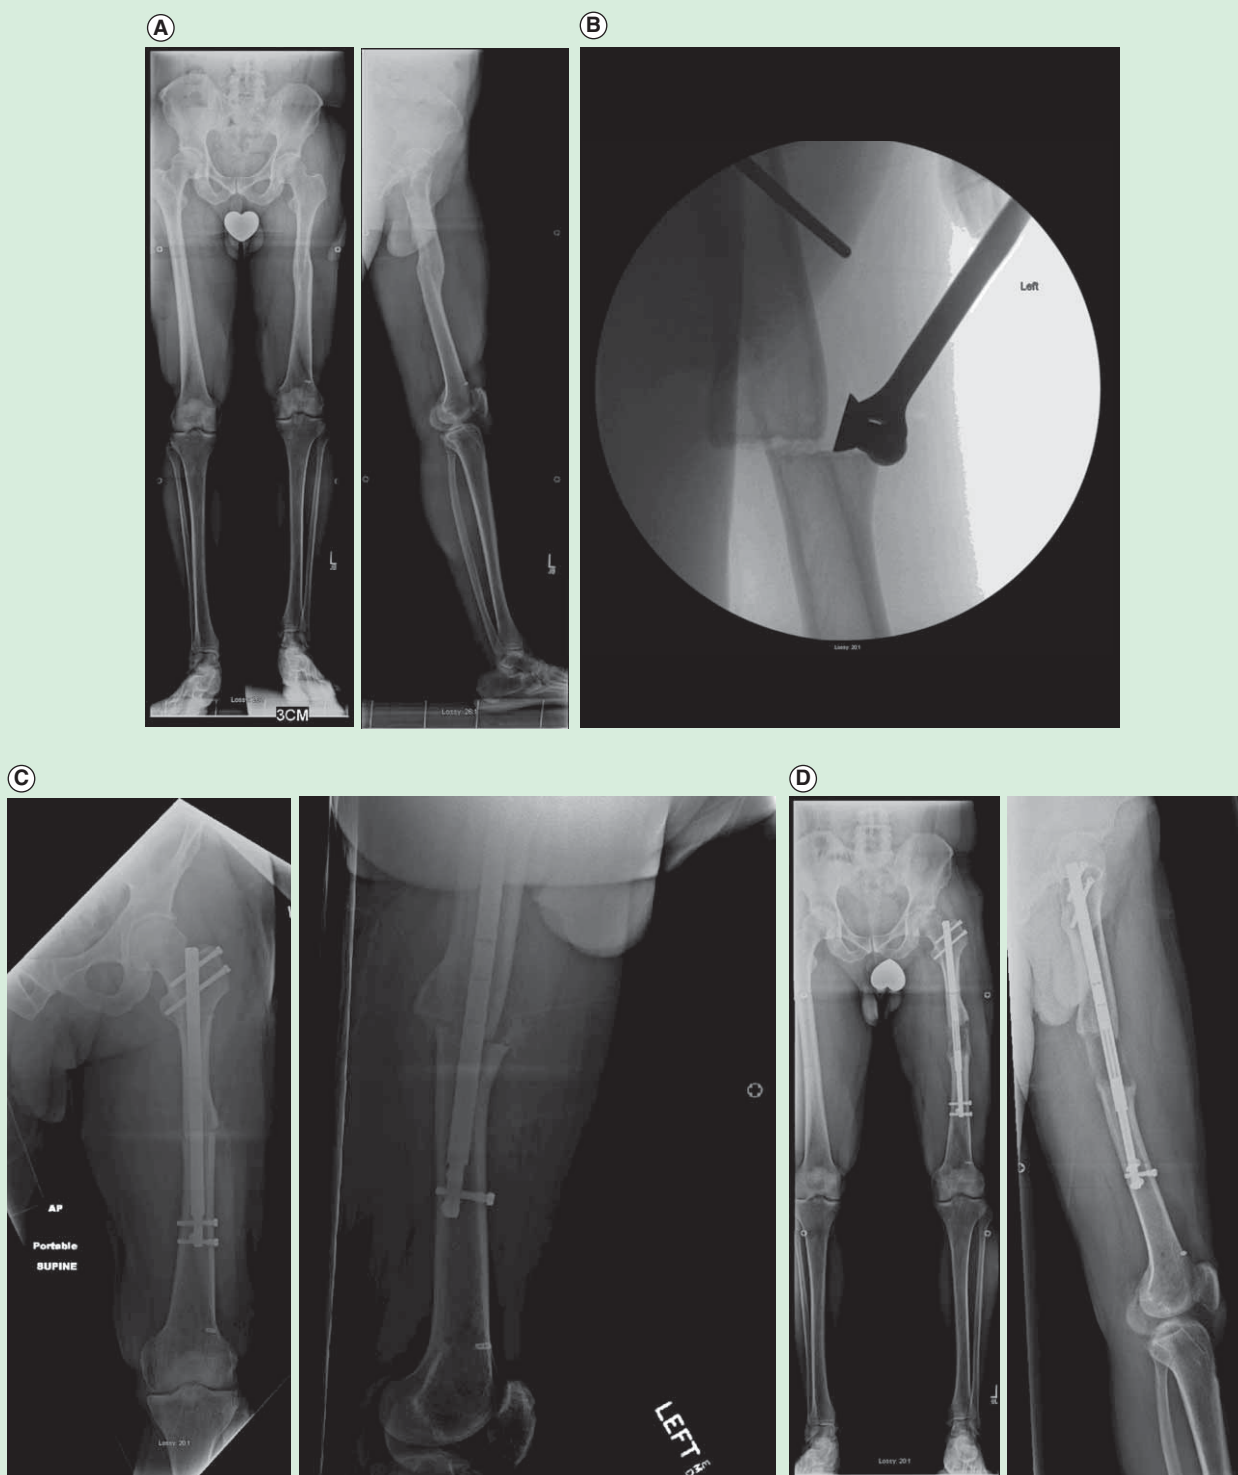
Forty-eight year old man with a symptomatic post-traumatic 5 cms LLD of the femur. (A) Preoperative AP and lateral radiographs of the femur. (B) Using fixator assistance, the osteotomy was made prior to reaming in order to realign the medullary canals of the previously bayonet deformity. (C) AP and lateral radiographs after insertion of Precice1 12.5 mms nail. The bayonet deformity is reduced. (D) AP and lateral radiographs after 5cms of lengthening. Good bone healing is seen. He proceeded to heal completely.
